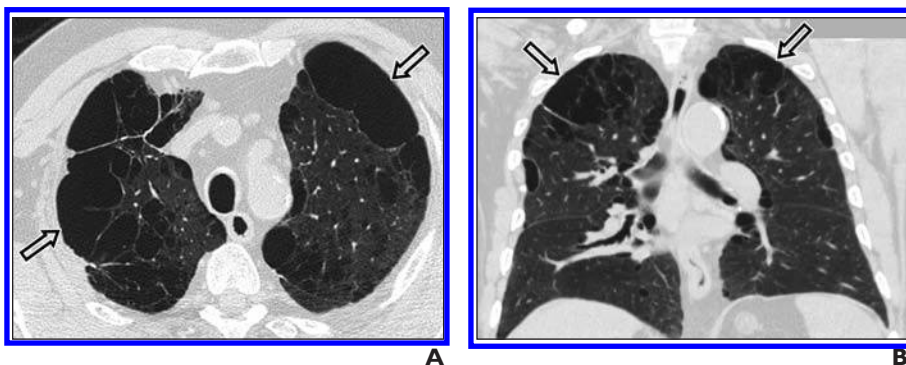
Paraseptal emphysema. A and B, Transverse (A) and coronal (B) CT images of chest show destruction of lung parenchyma with distinct bullous changes (*arrows*) that predominate in subpleural regions of upper lobes.
